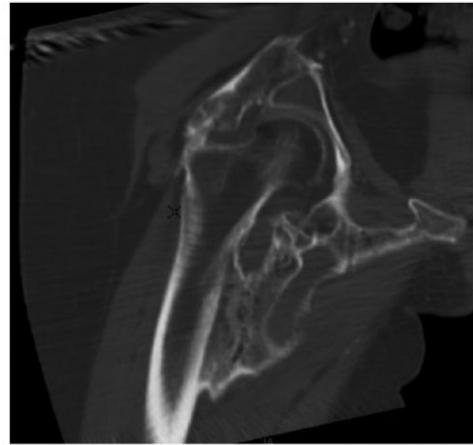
Computerized tomography (CT) coronal slice showing a conserved joint despite extensive ossification.
